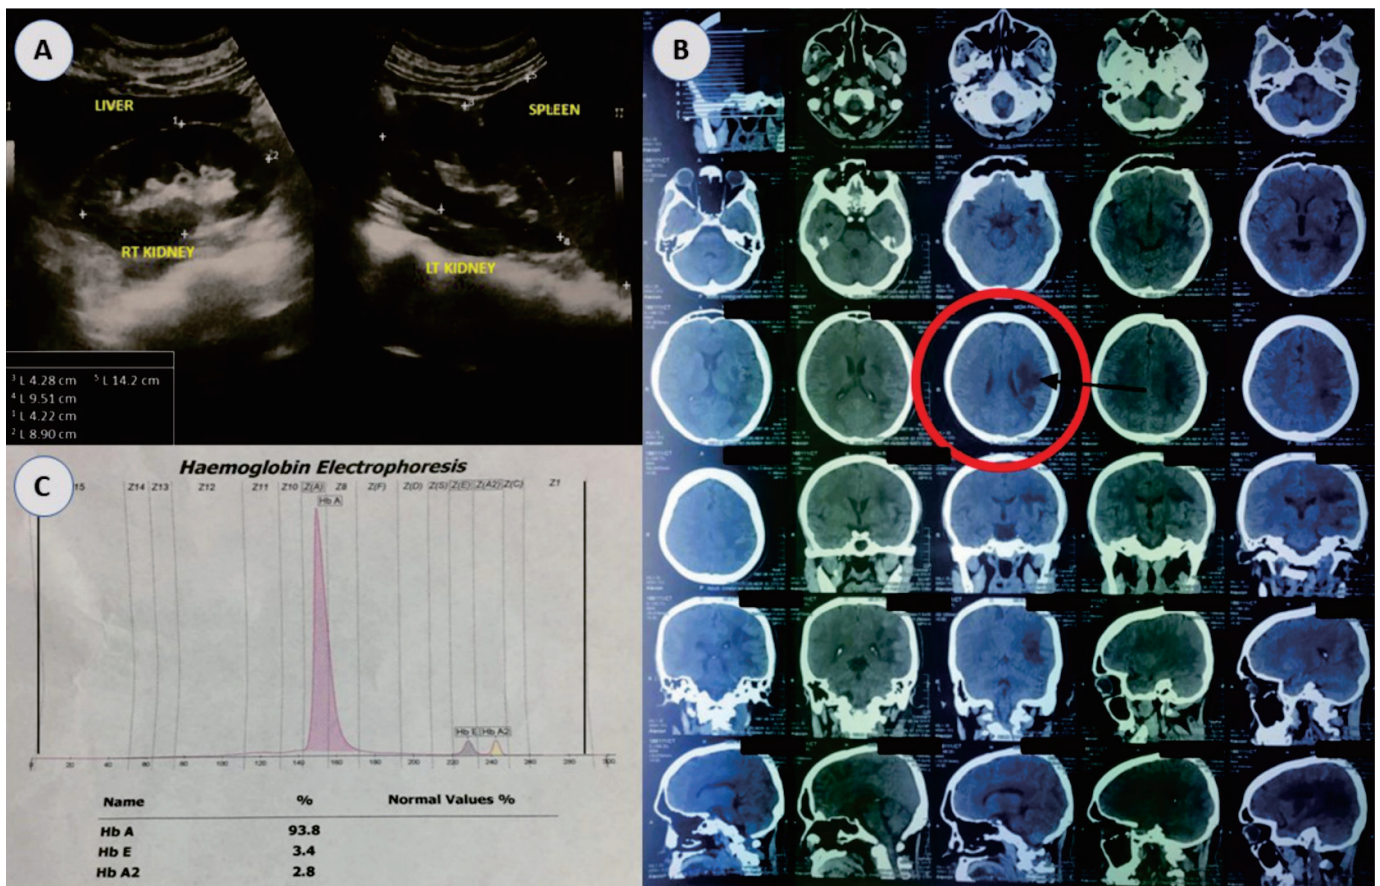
(A) Abdominal ultrasound examination; shows splenomegaly was found with a size of ± 14.2 cm, other organs were no abnormalities. (B) Head CT scan; shows the results showed hypodense lesions in the left corona radiata. There were no abnormalities with the conclusions of infarction at corona radiata as an embolic impression. (C) Haemoglobin Electrophoresis showed HbE-pathy
